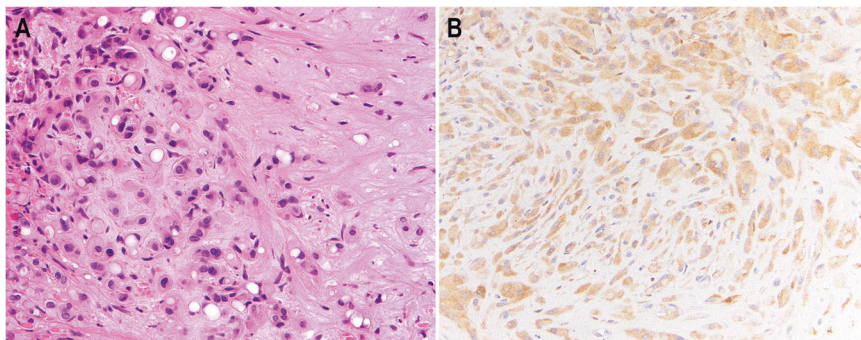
Conventional EHE (*CAMTA1* rearranged). A In this case, there are tumor cells with occasional cytoplasmic vacuoles arranged as cords and single cells in a myxohyaline stroma. B There is diffuse, retained cytoplasmic expression of YAP1-CT.
